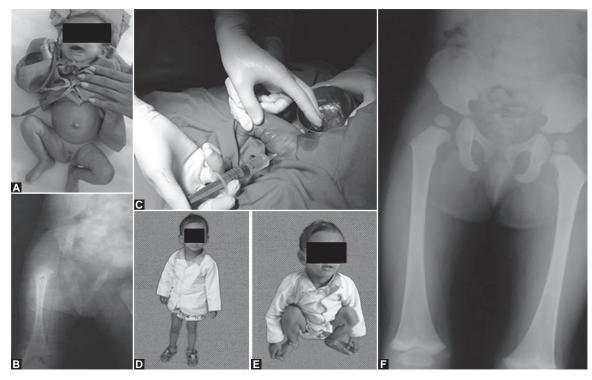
A, Clinical photograph of a 28-day-old neonate with septic arthritis right hip. There is fixed flexion deformity at right hip and painful movements of right lower limb. B, X-ray shows right hip dislocation as well as lytic changes in proximal femur. C, Joint wash of the right hip was done by mini-invasive technique using 16 G needles through multiple ports. This was followed by course of intravenous and then oral antibiotics. D, and E, Clinical photographs showing two and half year follow-up with full range of movement at right hip joint and no limb length discrepancy. F, X-ray done at two and half years suggests normal recovery; no growth arrest, no limb length discrepancy
